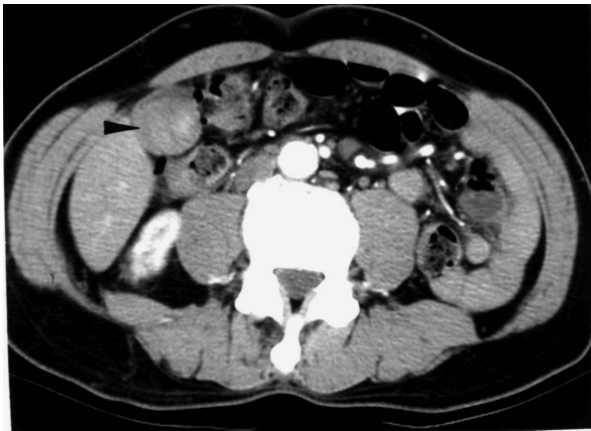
Computed tomography showing a non-enhanced tumor-like lesion (arrowhead) in the gallbladder after contrast enhancement.
